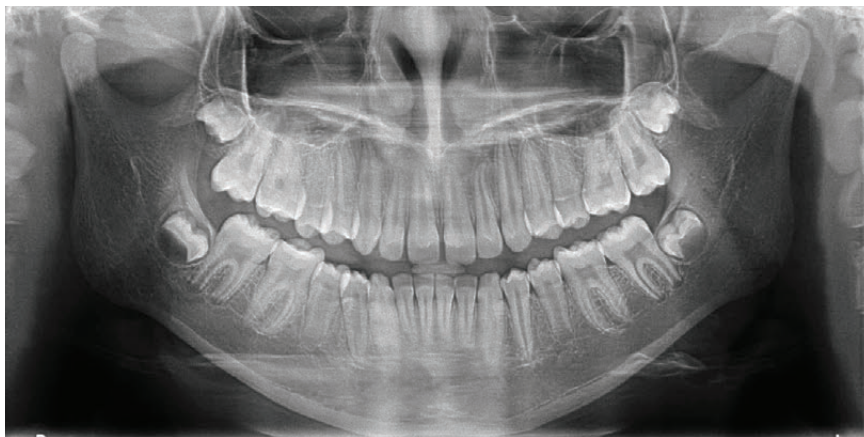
Pre-treatment orthopantomogram.
